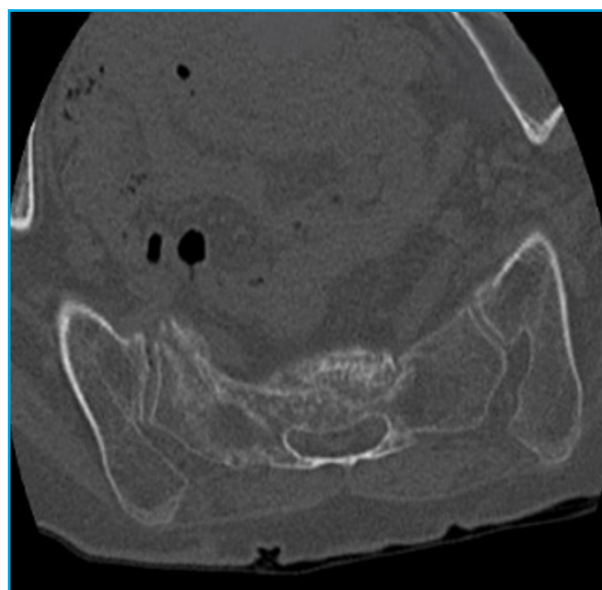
CT images in an oblique coronal plane.
